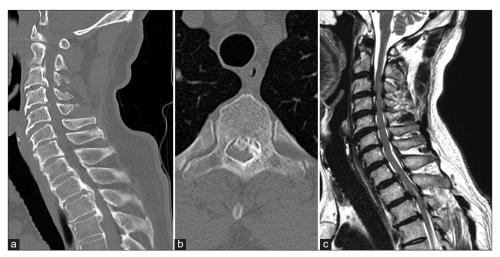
Images before the initial surgery. (a) CT sagittal image showed OPLL. (b) Ossification lesion at the T2-3 level. (c) MRI showed hyperintense changes of the spinal cord at C3-4 and T2-3 levels. CT: Computed tomography, MRI: Magnetic resonance imaging, OPLL: Ossification of the posterior longitudinal ligament.
